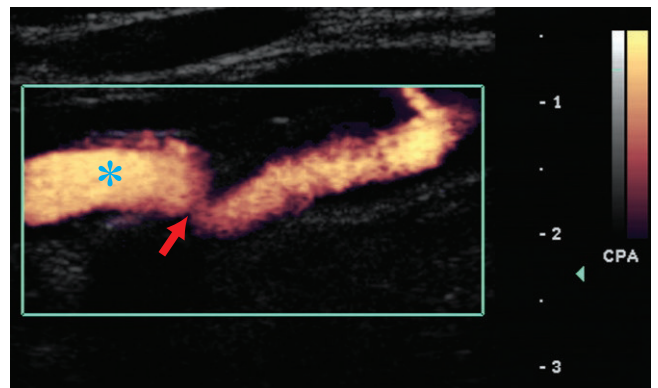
Power Doppler of the mid internal carotid artery shows the area of narrowing (arrow) and poststenotic dilatation (*). Power Doppler does not alias. The contour of the vessel is shown better without the aliasing artifact.
